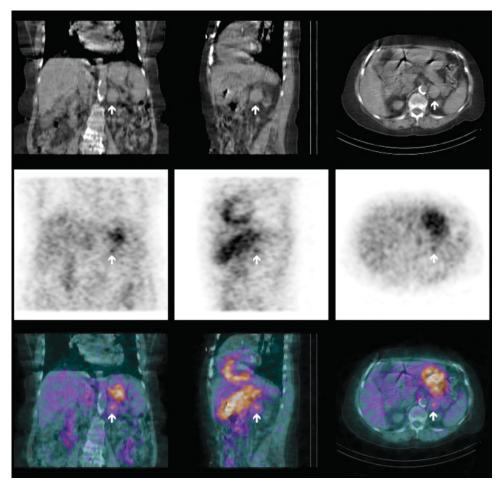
New advance of image-rendering display: thallium-201 SPECT/CT. The coronal (left column), sagittal (middle column) and transaxial (right column) views of the CT images (top row) and corresponding SPECT images (middle row) fused to the SPECT/CT images (bottom row) are displayed. The arrows indicate the significant lesion in the left adrenal medulla.
